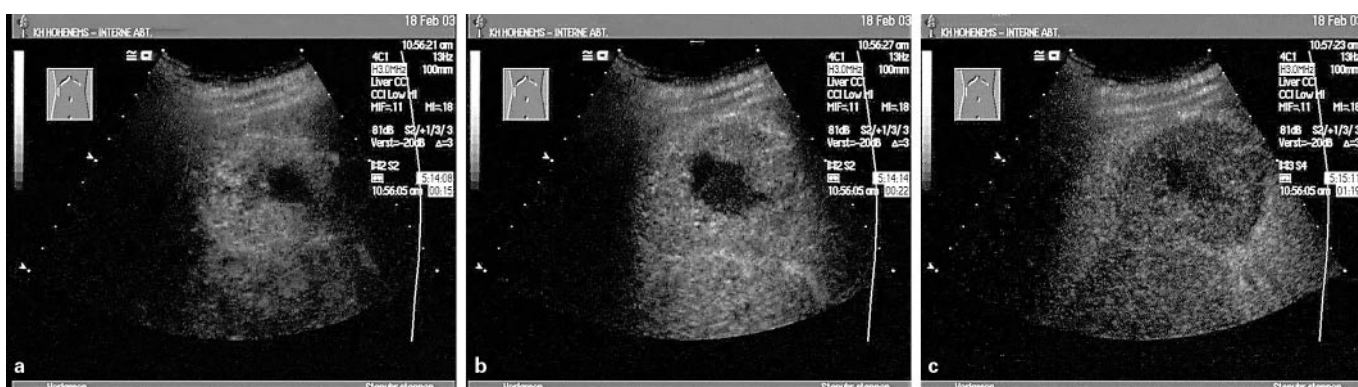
Metastasis with mixed vascularisation pattern in contrast-enhanced ultrasound. 15 s after injection a hyperchoic lesion with a central lack of contrast enhancement is visible (a). 22 s after injection the lesion is isochoic, except for the central area (b) and at 1 min 19 s the lesion becomes hypochoic (c).
